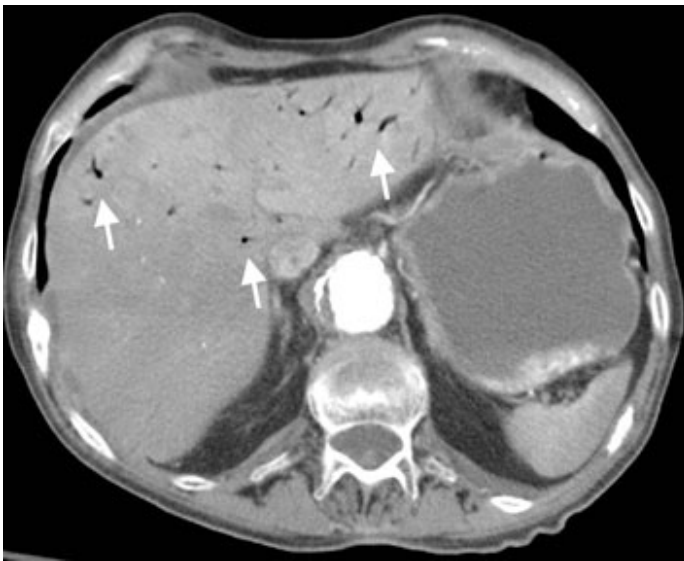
IV contrast-enhanced CT scan in a patient with acute transmural mesenteric infarction demonstrating pronounced intrahepatic portal venous gas (arrows).
